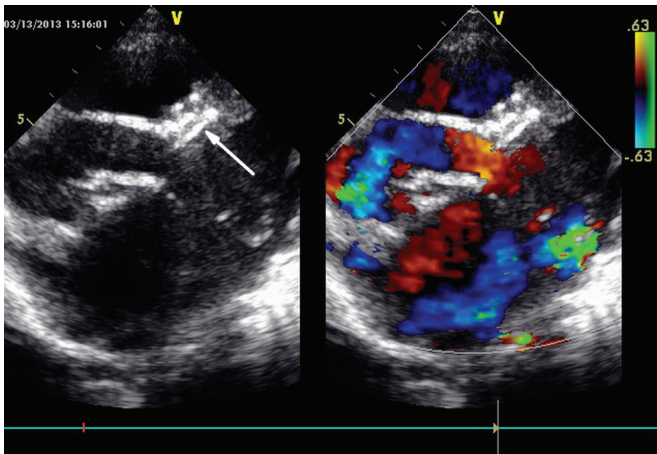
Left: Follow-up transthoracic echocardiography showing that the occluder was stable (arrow). Right: Follow-up transthoracic echocardiography showing no R-VSD shunt.
